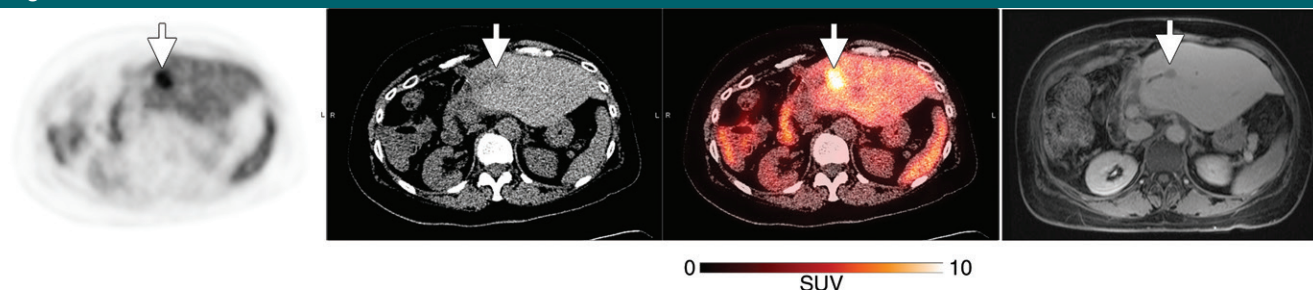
$^{18}\text{F}$ -FTT PET (left), unenhanced CT (middle), and fused transaxial (right) images in 52-year-old man with recurrent pancreatic adenocarcinoma after Whipple procedure (subject 2, Table 2). Images were obtained 30 minutes after tracer injection. Arrows indicate location of recurrent pancreatic cancer. Gray-scale PET images were set to same scale as that shown for color image. SUV = standardized uptake value.
